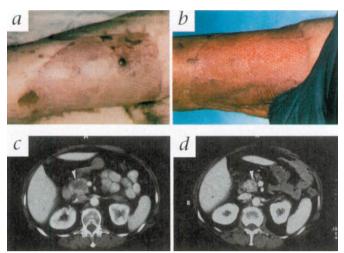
Clinical responses to DC-based vaccination. Right leg (ventral thigh) of patient 4 with multiple erythematous skin metastases in an area of previous surgery before (a) and after (b) 6 cycles of vaccination with tumor lysate-pulsed DCs. The patient experienced a complete response with disappearance of all skin metastases, as well as lung metastases. CT scan of patient 1 with large pancreatic metastasis (white arrow) before (c) (dark tumor area: 30×20 mm) and after (d) (dark area: 10×8 mm) 6 cycles of vaccination with A2-peptides-pulsed DCs.
